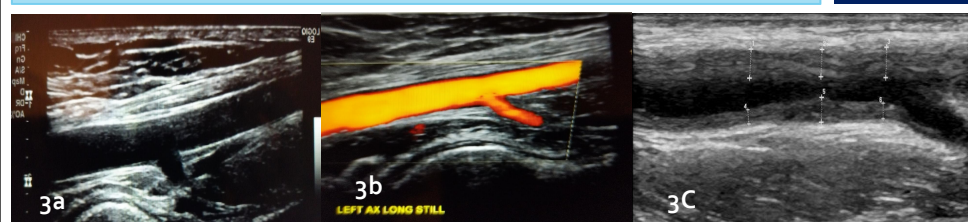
Demonstrating a normal axillary artery (longitudinal view). 3b: Normal axillary artery with Power Doppler assessment. 3c: Abnormally thickened wall (intima media thickness of 1.3mm) with a visible hypochoic halo (calipers demonstrate abnormal wall thickening).
